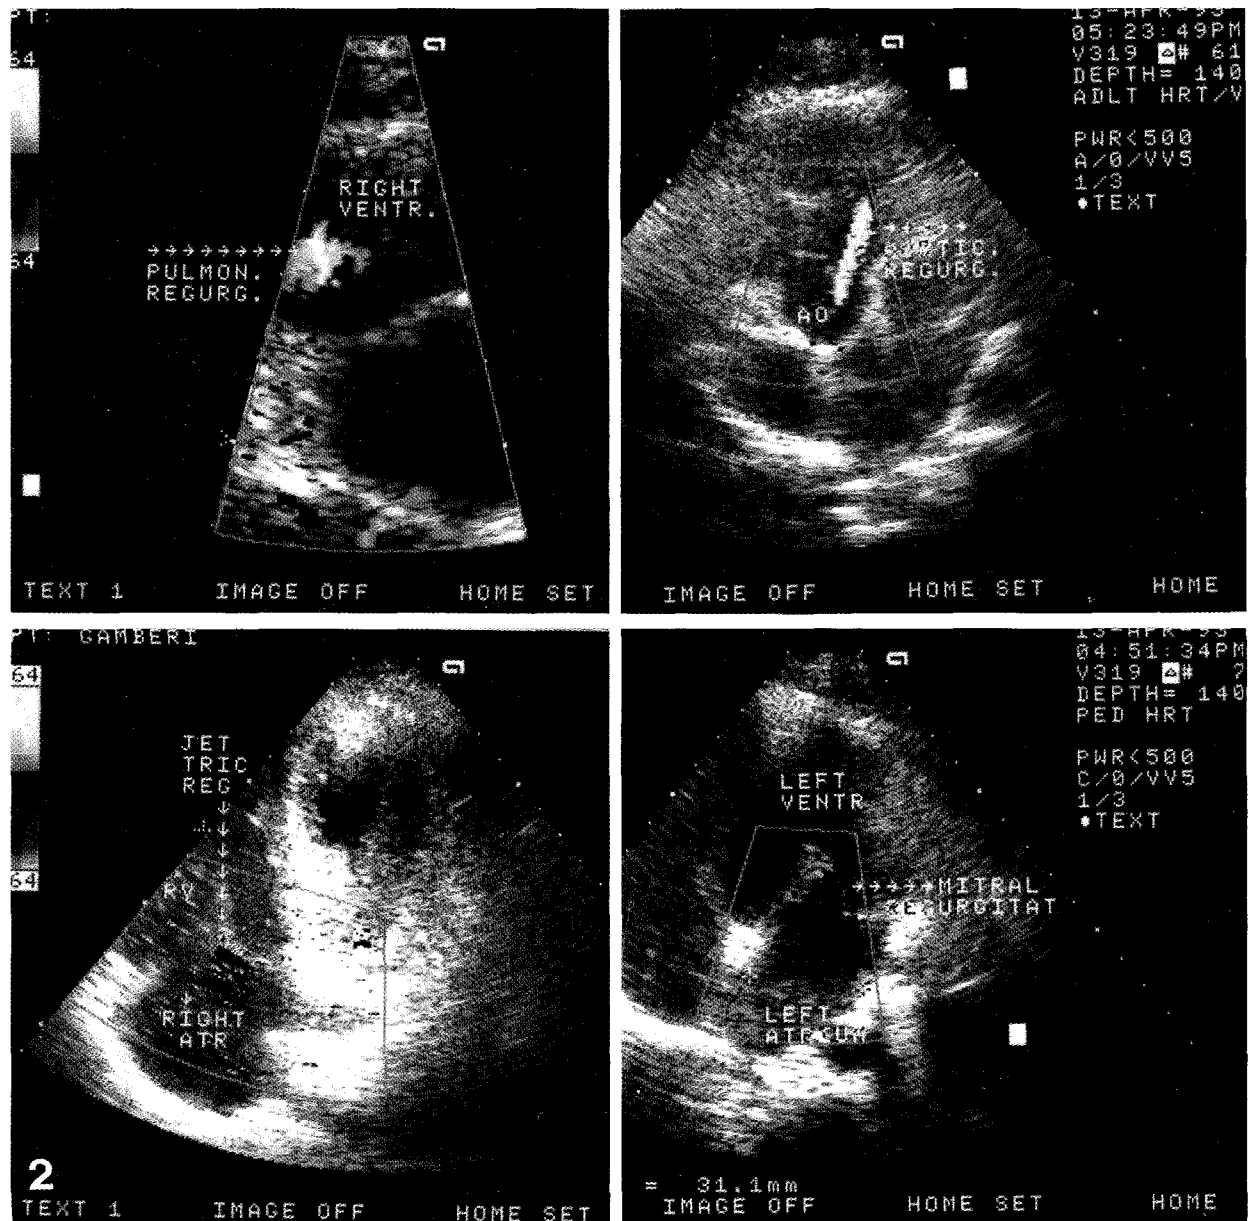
Echo color-doppler of four subjects with valvular regurgitation.
